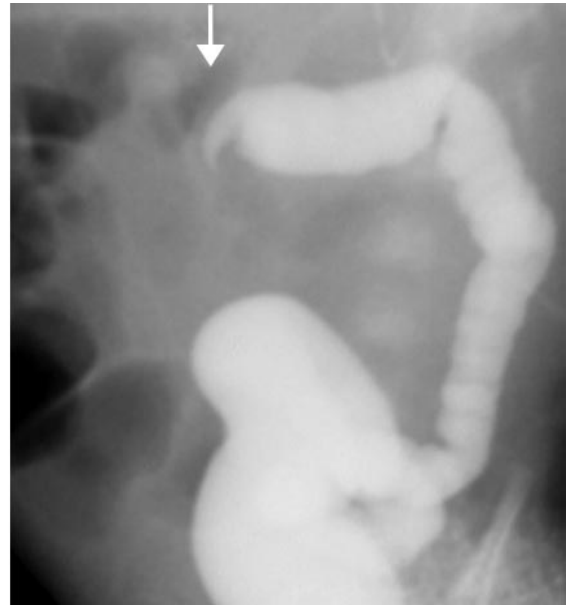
Malrotation in a 5-year-old girl. Delayed radiograph, obtained after an upper GI series, shows a markedly abnormal location of the cecum and appendix (arrow) in the epigastric region, a finding that implies a very short small-bowel mesentery and a high risk for volvulus. Barium outlines the entire colon, which is located in the left side of the abdomen. Note the gastrojejunal feeding tube, which follows the course of the duodenum and proximal jejunum. The distance between the cecum and the duodenojejunal junction (arrowhead) is very short.
